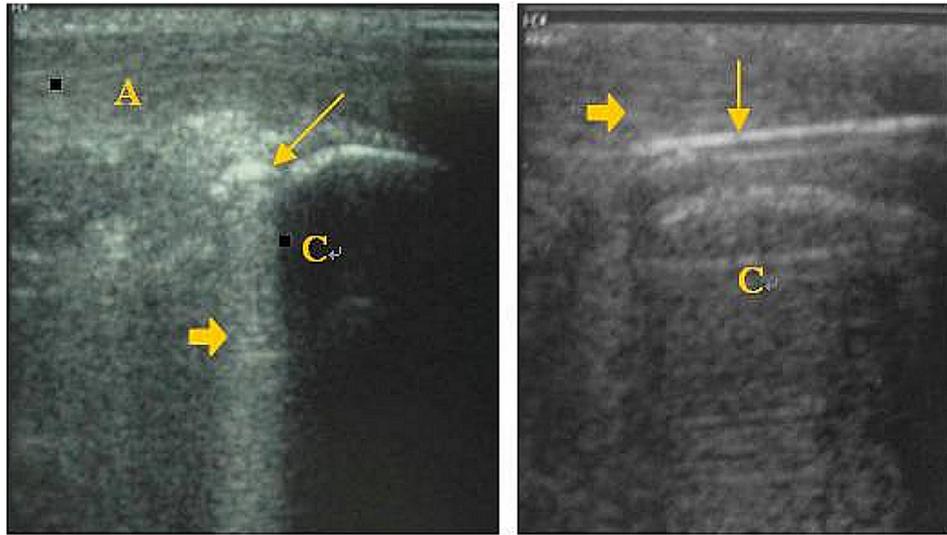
Left: Intraoperative ultrasonogram of the posterior heel. The micropunch is visible between the Achilles tendon and calcaneus (arrow). The comet tail sign (arrowheads) beneath the micropunch was an ultrasound artifact caused by the metallic endoscopic tool. Right: Ultrasound-guided multiple puncture and longitudinal tenotomy of the calcified tendinopathy. The K-wire (arrow) is visible within the Achilles tendon substance (arrowheads). A, Achilles tendon; C, calcaneus.
